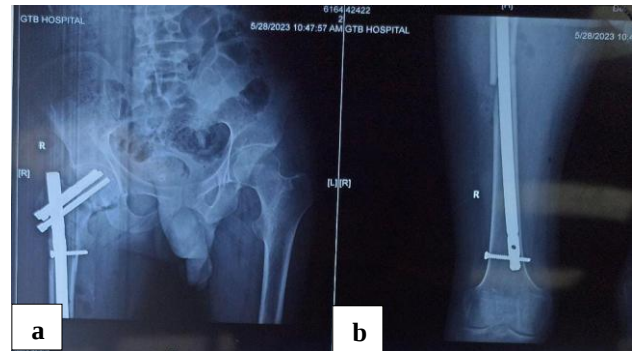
(a and b): Post op radiograph with internal fixation using a sirius nail.
